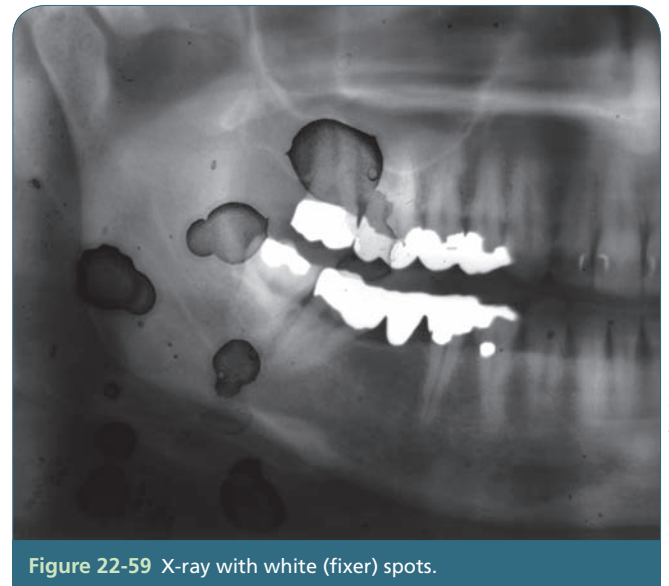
X-ray with white (fixer) spots.
